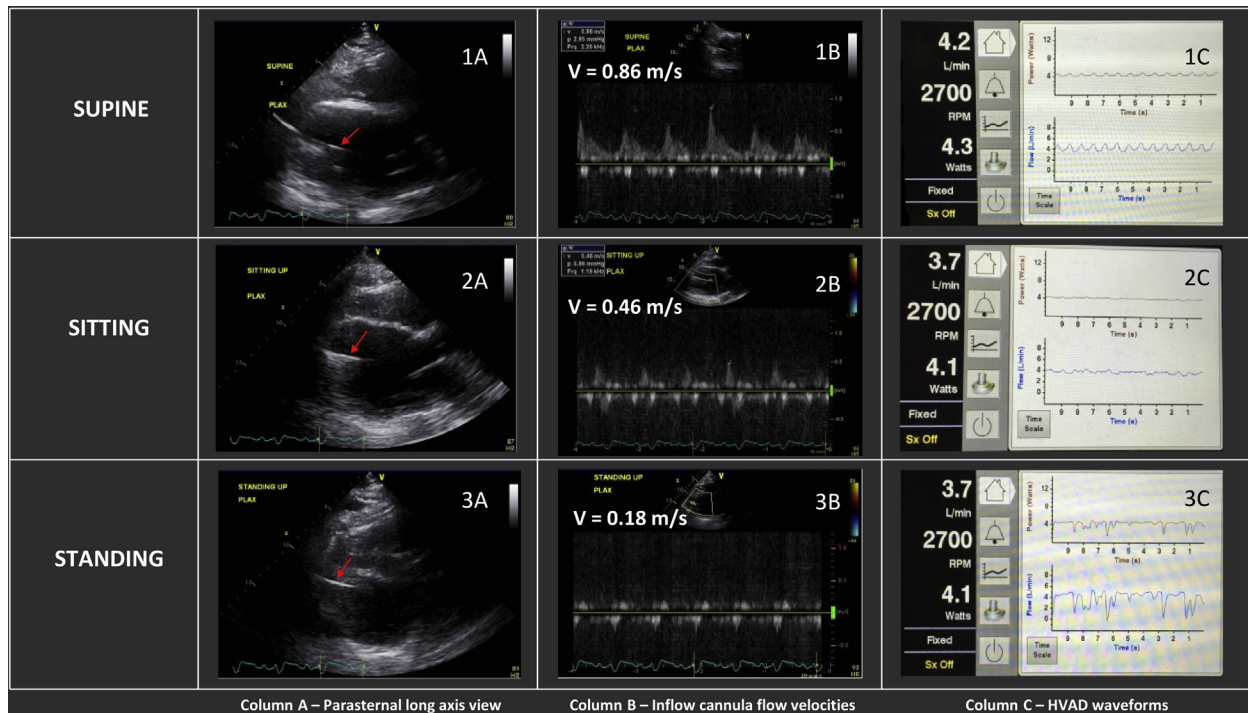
Transthoracic echocardiography showing LV size and inflow cannula velocities along with HVAD waveforms at each position (supine, sitting, and standing). The *arrows* in column A point to the inflow cannula.
